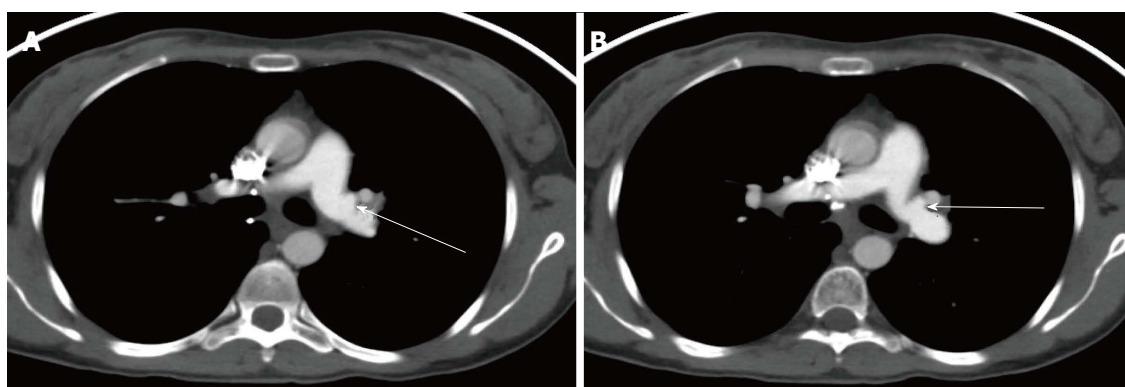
Computerised tomography scan of the chest in a 31-year-old female 3 mo post bilateral lung transplantation showing peri-anastomotic left pulmonary artery saccular aneurysm. A: Axial slice of CT chest image showing a left pulmonary artery saccular aneurysm (arrow); B: Axial slice of CT chest image showing a left pulmonary artery saccular aneurysm (arrow). CT: Computerised tomography.
